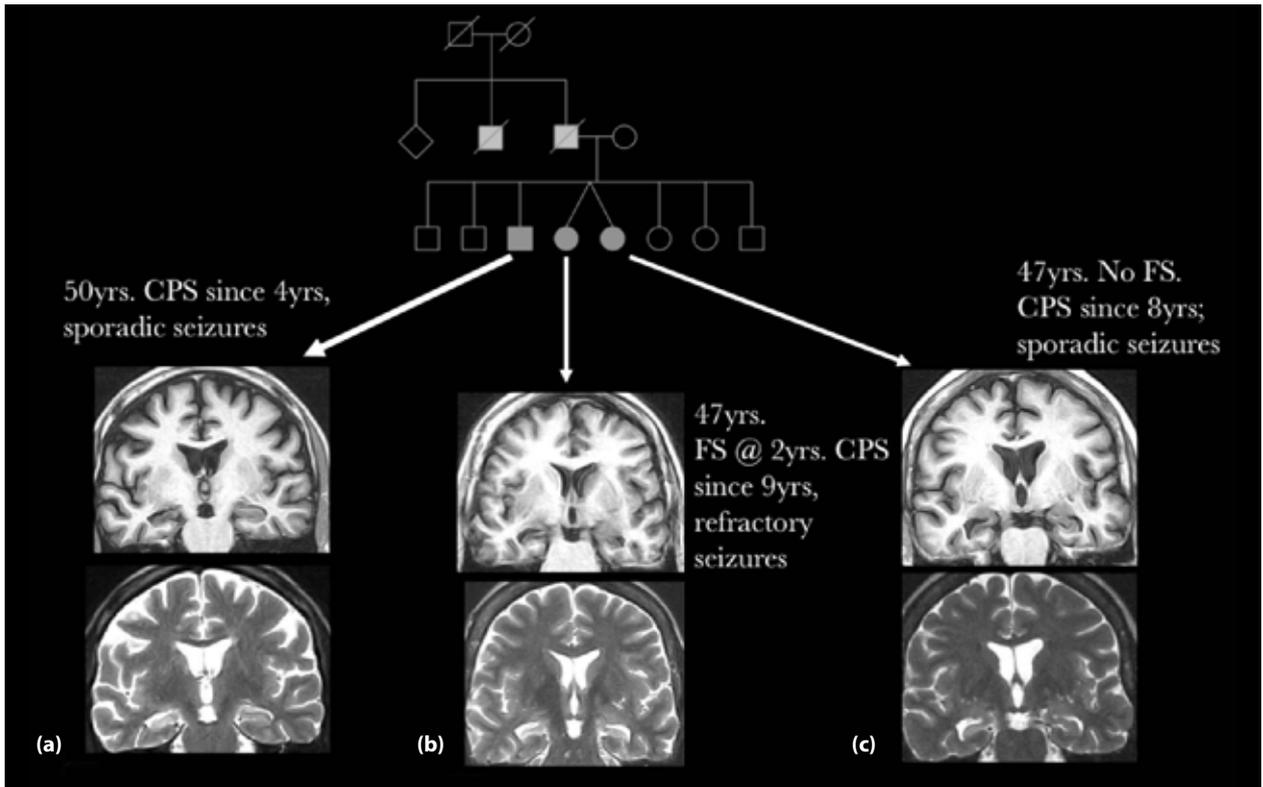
T1 and T2 MRI sequences in coronal slices showing familiar MTLE with right HS (a, c) and bilateral HS (b).
